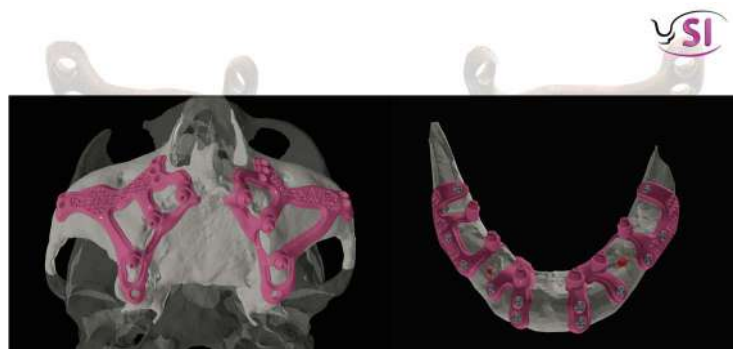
Examples of maxillary (left) and mandibular (right) custom-made digital subperiosteal implant designs. Each implant is individually designed from CBCT-derived 3D models to match the patient's anatomy and provide stable fixation in cases of severe jaw atrophy.
